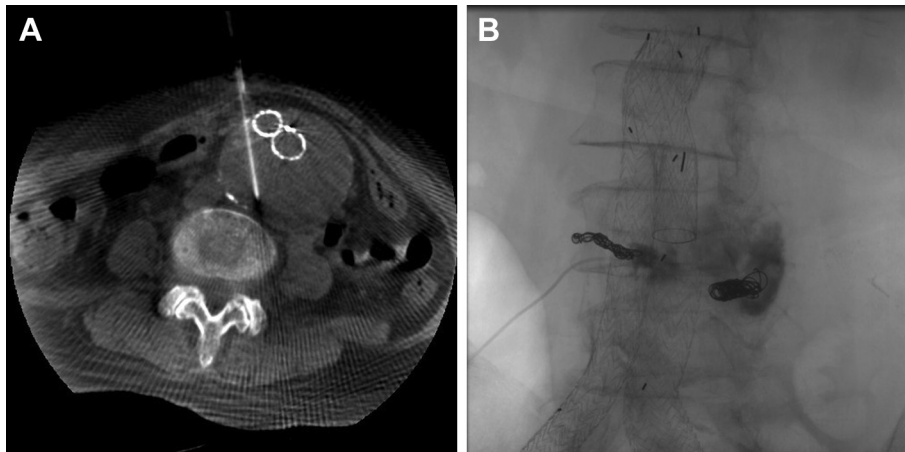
A, An 18-gauge needle was placed transabdominally in the aneurysm sac, guided by real-time computed tomography (CT). B, Angiography showing coiling in the sac and lumbar artery after treatment of the new type II endoleak.
